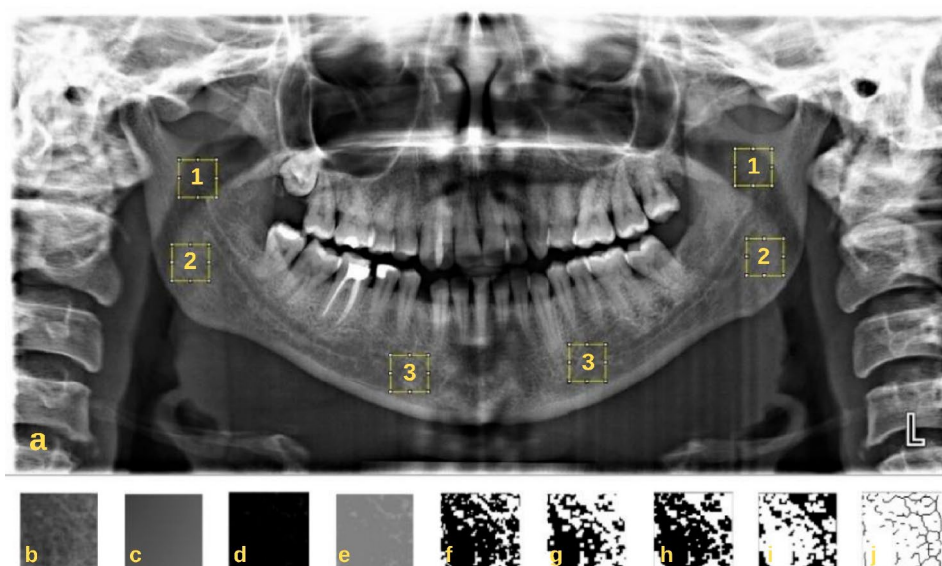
a: Panoramic radiograph with the three selected region of interest areas (ROIs) bilaterally; 1: the geometric center of the area between the mandibular notch and mandibular foramen (ROI 1) 2: the geometric center of the mandibular angle where the mandibular body and ramus intersect (ROI 2) 3: the region mesial to the mental foramen (ROI 3); b: cropped and duplicated image; c: gaussian blurred image; d: subtraction image; e: an added 128 image; f: binarization; g: erosion; h: dilation; i: inversion; j: skeletonization
